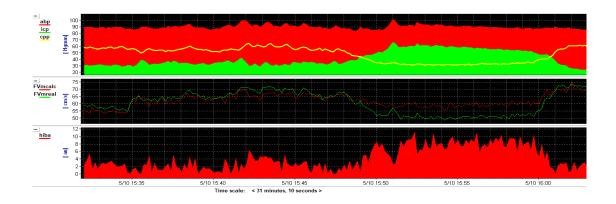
Transcranial Doppler (TCD), arterial blood pressure (ABP) and intracranial pressure (ICP) monitoring using ICM+ software. On the upper panel a drastic, 15 min long rise in ICP (plateau wave) is visible together with a constant ABP and the consequent drop in cerebral perfusion pressure (CPP). The middle panel shows the mean flow velocity in the middle cerebral arteries calculated with both the traditional (FVmcalc) formula and the time-integral of the current flow velocities (FVmreal). The difference between the two parameters is visible in the lower panel. An increase in the error coincide with the plateau wave.
